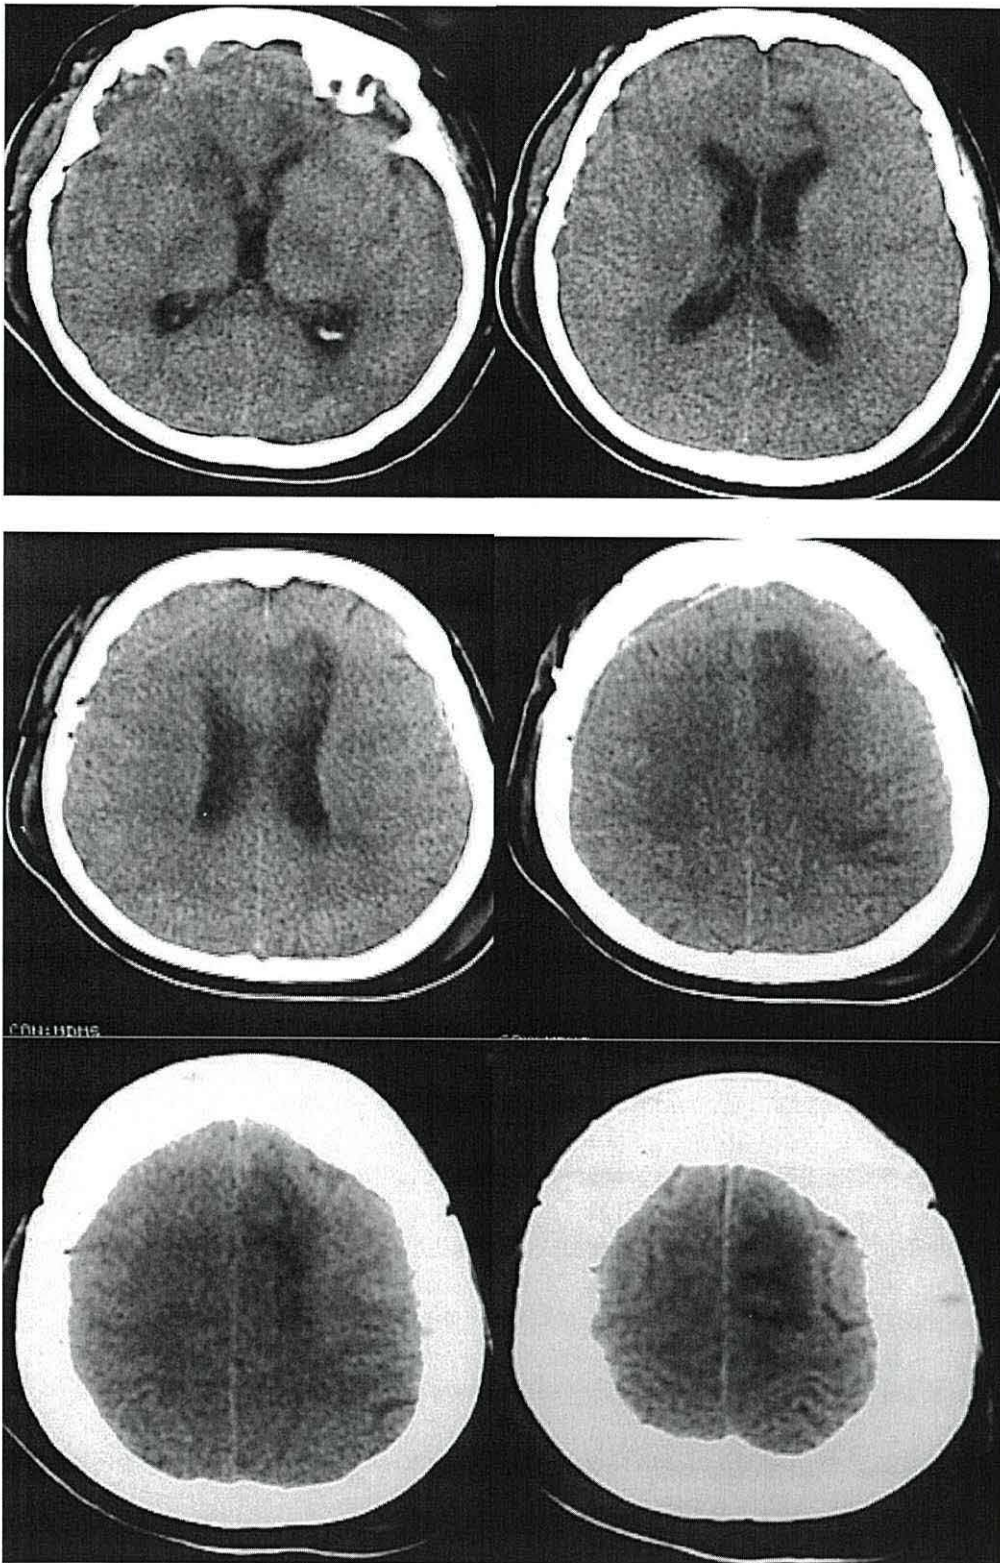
CT scans for patient DT, who suffered a subarachnoid haemorrhage; an ACA aneurysm was subsequently clipped. Lesions appear to be predominately in the left hemisphere.
